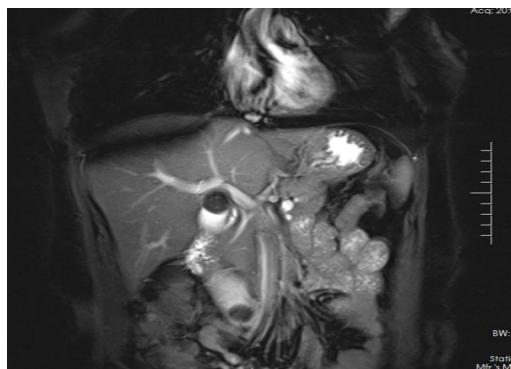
MRI+MRCP诊断为I型MS患者影像学资料
